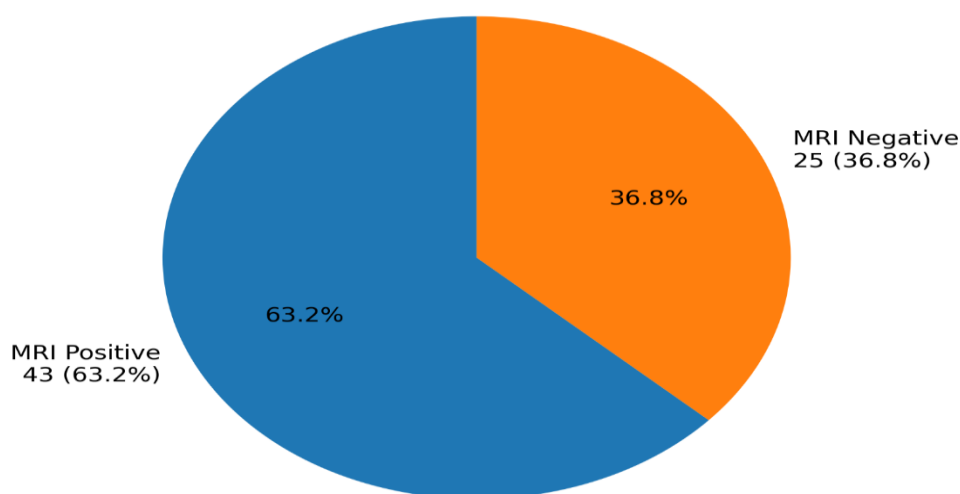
Distribution of positive and negative contrast-enhanced FLAIR MRI findings among study participants (n=68).
